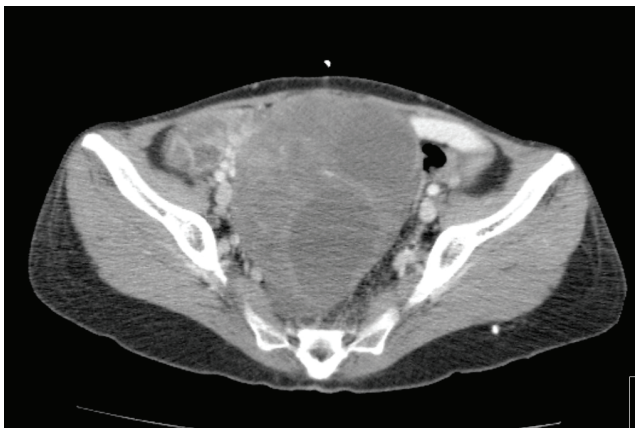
Computed tomography image of Krukenberg tumor
